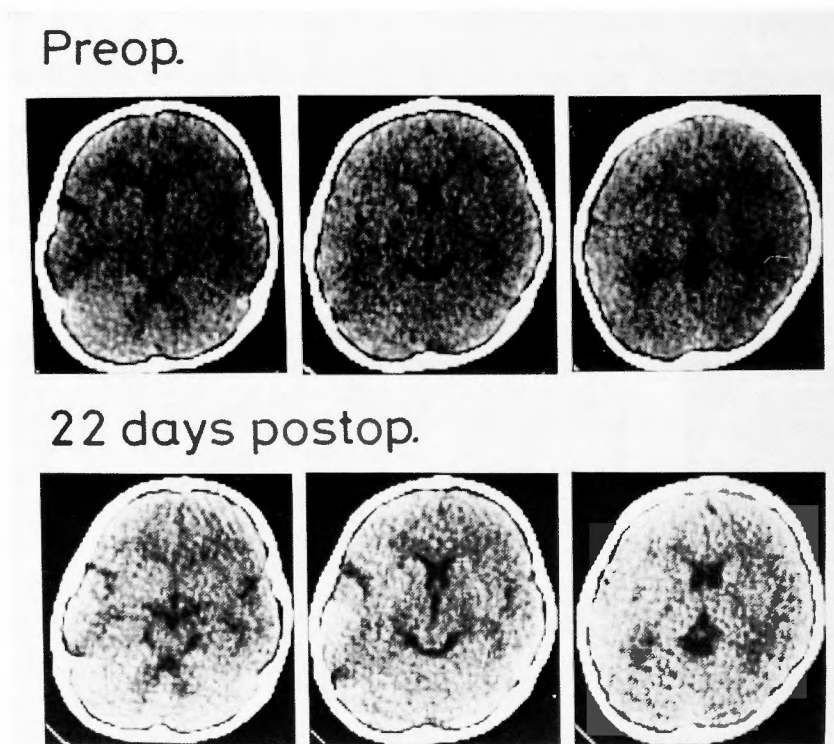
Preoperative and postoperative CT scans of the brain of a 4.3-year-old girl with congenital mitral regurgitation who underwent annuloplasty during 116 minutes of cardiopulmonary bypass with a bubble oxygenator; a 20μ filter was in place in the arterial line. No postoperative changes were noted.
